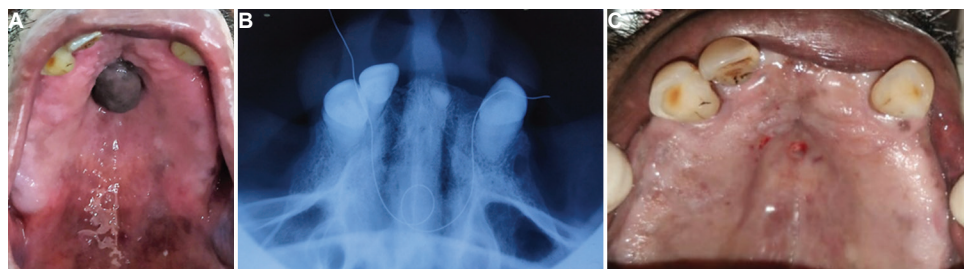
(A) Pre-operative picture showing growth in the mid-palate. (B) Occlusal radiograph with string showing no bony involvement. (C) Picture showing immediately after excision of growth in the mid-palate.
